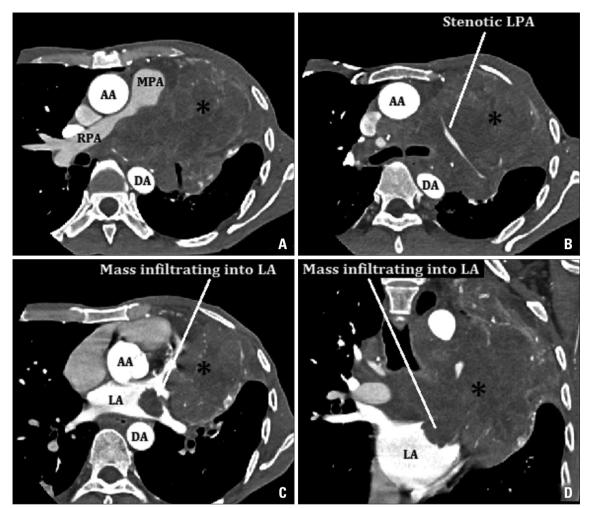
Multidetector computed tomography with contrast showing a large mass (indicated by \*) in the upper left pulmonary zone encroaching upon and causing severe extrinsic compression of the RPA and LPA as shown in the axial sections (A and B). The mass has infiltrated into the left atrium in the form of a pedunculated growth as seen in the axial section (C) and in the coronal section (D). AA: ascending aorta, DA: descending aorta, LA: left atrium, LPA: left pulmonary artery, RPA: right pulmonary artery, MPA: main pulmonary artery.
